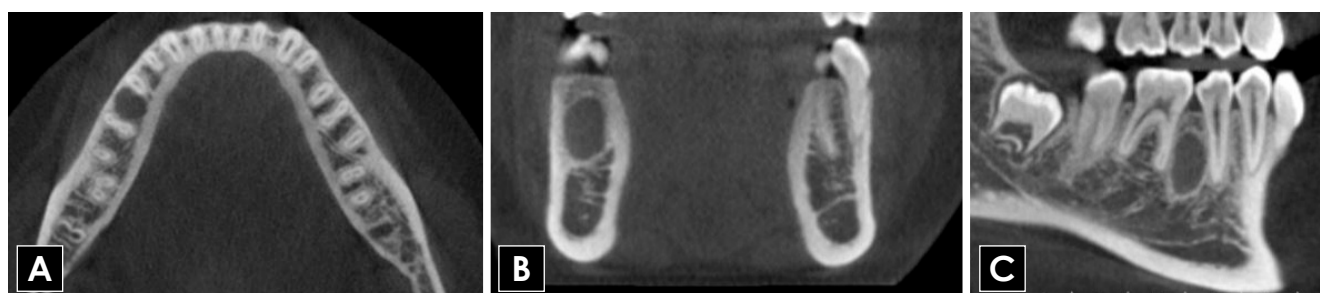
Axial (A), coronal (B), and sagittal (C) CBCT images of a hybrid CGCG with CODF lesion showing a well-defined, corticated, unilocular, low-density lesion in the posterior right side of the mandible. CBCT: cone-beam computed tomography, CGCG: central giant cell granuloma, CODF, central odontogenic fibroma.
